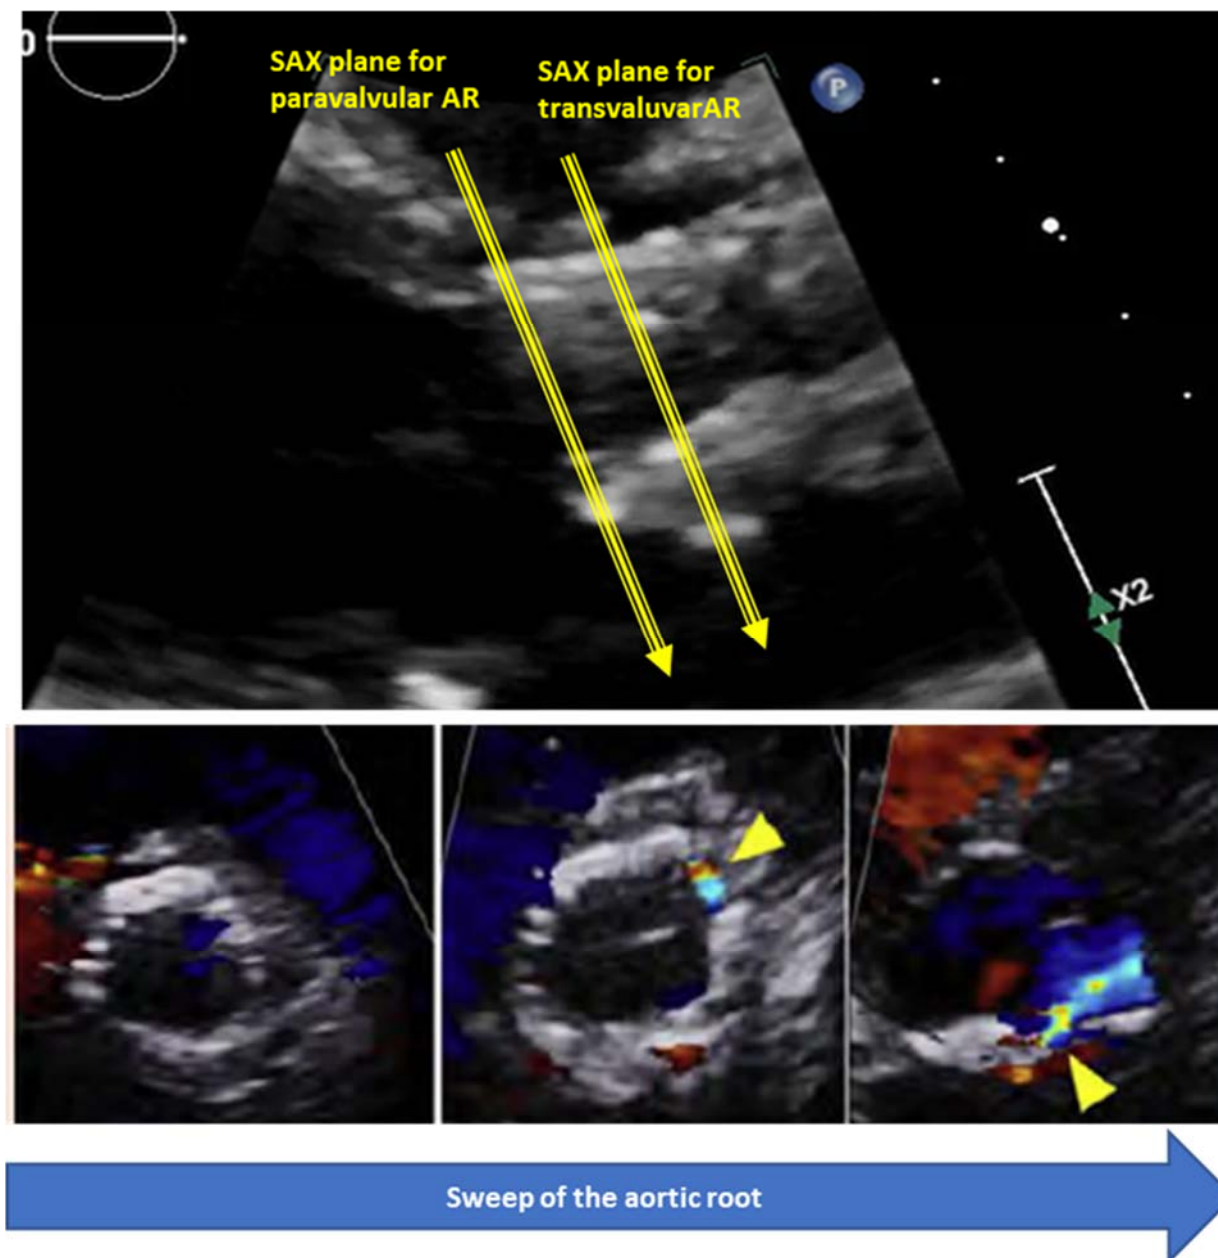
Imaging planes for detection for paravalvular and transvalvular regurgitation. Thorough imaging of the entire valve is needed to identify the origin and vena contracta of regurgitant jets, which may be multiple and not be all at the same level. A sweep of the aortic root from the parasternal SAX view is recommended. [Journal of the American Society of Echocardiography 2019 32:431-475 DOI: (10.1016/j.echo.2019.01.003, Copyright © 2019 American Society of Echocardiography]
